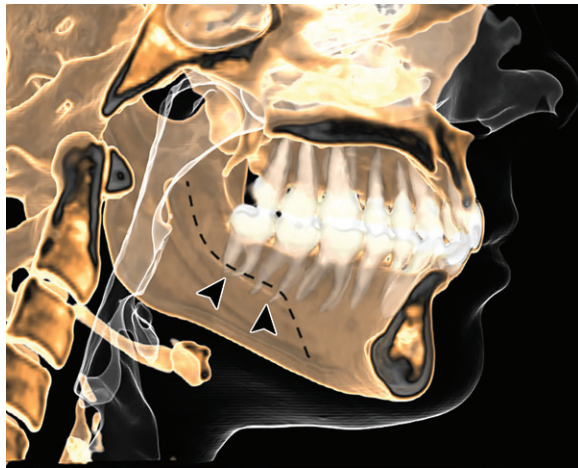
Mylohyoid line. Three-dimensional volume-rendered CT image shows the attachment of the mylohyoid muscle to the internal surface of the mandible (dashed line). It lies above the root apices of the second and third molars (arrowheads) and below the root apices of the other teeth. (Courtesy of Fábio Augusto Ribeiro Dalprá, MD, Hospital Israelita Albert Einstein, São Paulo, Brazil.)
